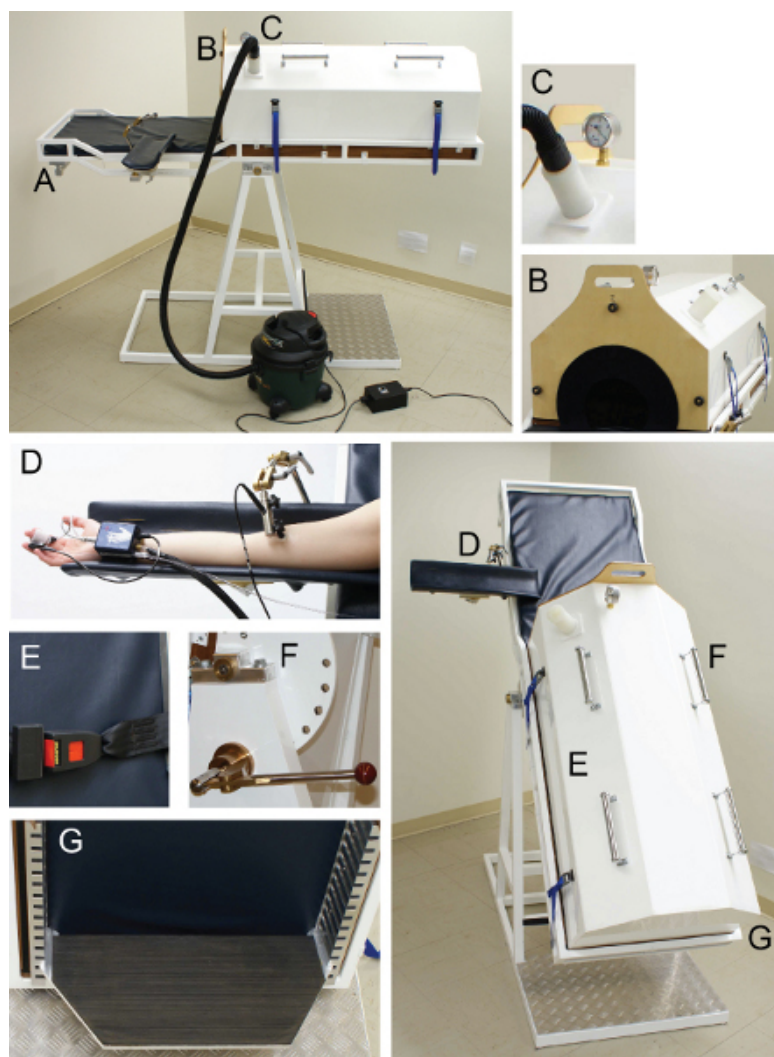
The manual, adjustable head-up tilt table and LBNP chamber. The manual design allows for rapid transitions between supine and tilt, ensuring the prompt recovery of presyncopal symptoms at test termination. A. The handle used to move the table into different positions. B. A pressure gauge monitors the level of LBNP during the protocol. C. A wooden waist board with neoprene is attached to the top of the chamber to ensure the chamber is air-tight. D. The adjustable arm rest with attached clamp for the brachial ultrasound probe. E. A seatbelt over the subject's legs minimizes skeletal muscle pumping activity during orthostatic stress. F. The lever used to adjust the table from -15 to 60° . G. The footplate can be adjusted for the subject's height once their iliac crest is positioned in the center of the table.
